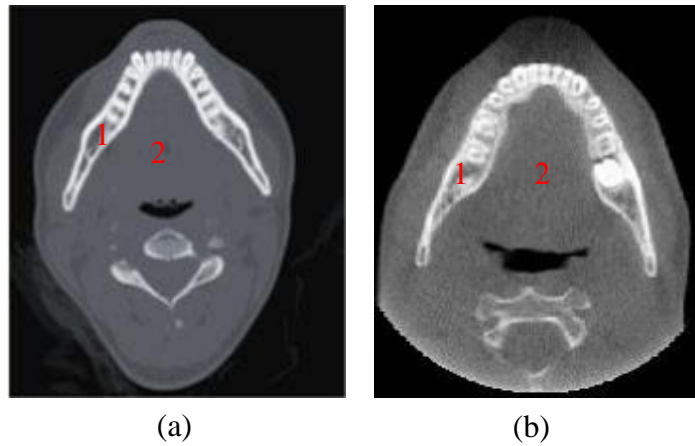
(a) Medical CT (MDCT) axial image (b) CBCT axial image (upper jaw) showing hard (1) and soft (2) tissues of maxilla. The low contrast of high density objects in the CBCT image is clear when compared with the MDCT structures [Modified from [36]].
